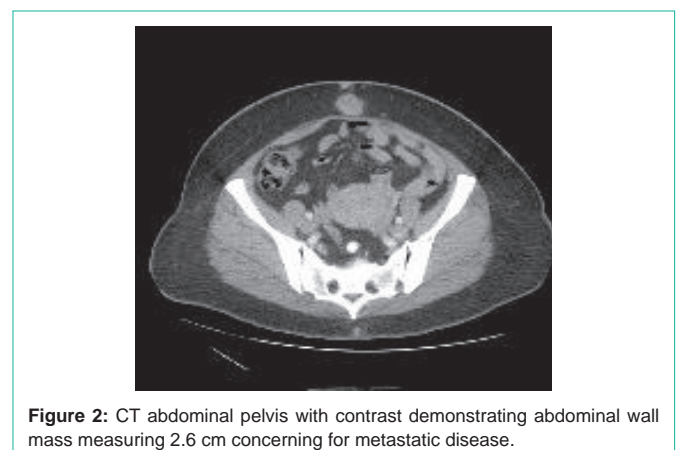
CT abdominal pelvis with contrast demonstrating abdominal wall mass measuring 2.6 cm concerning for metastatic disease.
